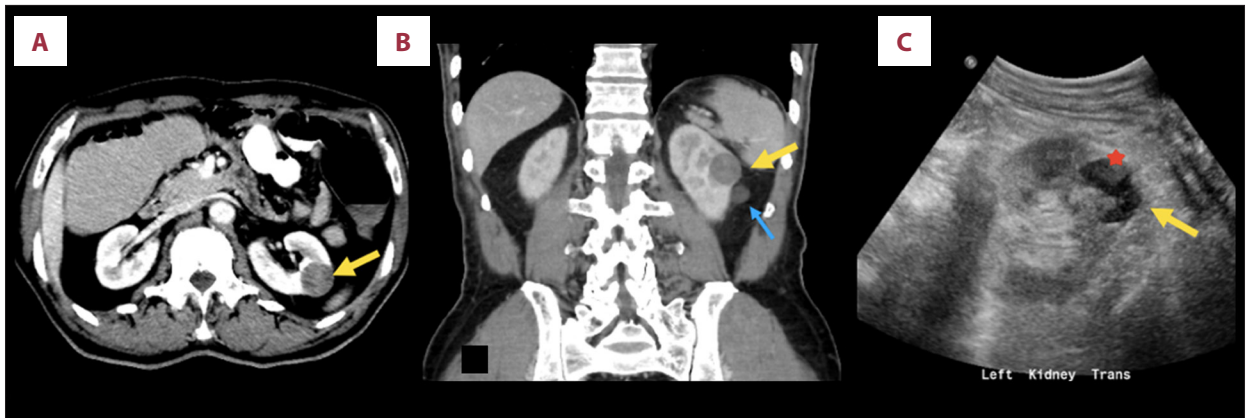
(A) Intravenous contrast-enhanced computed tomography scan at the level of the kidneys in the axial plane showing an incidental cortical exophytic interpolar renal lesion (yellow arrow) with enhancement that is suspicious for renal cell carcinoma. (B) Another smaller exophytic lesion (blue arrow) is seen in the coronal image of the left renal cortex with no enhancement, consistent with a cyst (blue arrow). (C) Ultrasonography performed on the same day showed the suspicious lesion (yellow arrow). The lesion's heterogenous echogenicity, solid component (red star), and lack of posterior acoustic shadow confirmed that it was solid.
